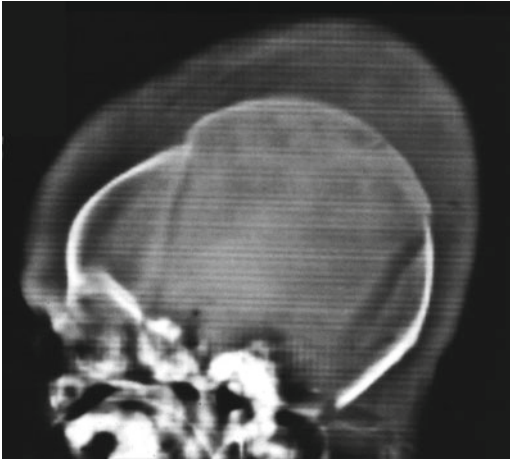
Lateral skull radiograph in an infant
